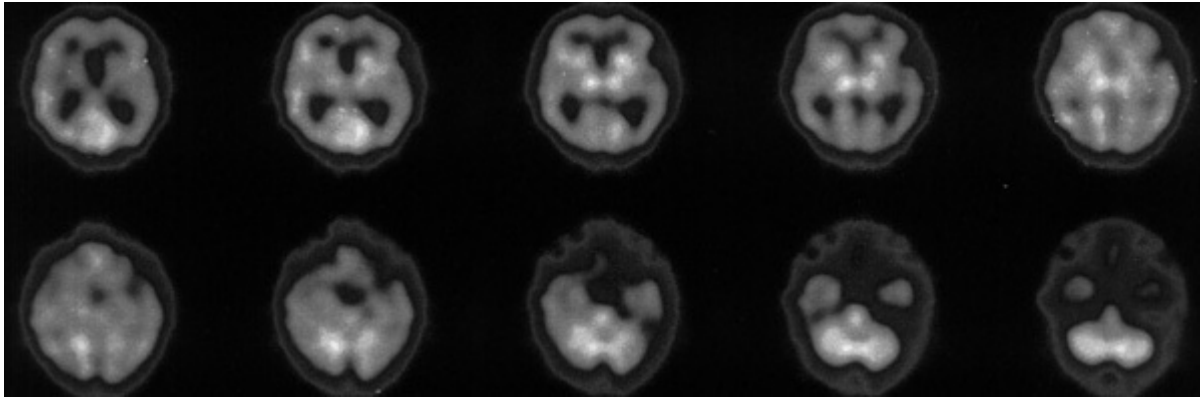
SPECT examination reveals hypoperfusion in the right caudate nucleus and bilateral frontotemporo-parietal cortex.
